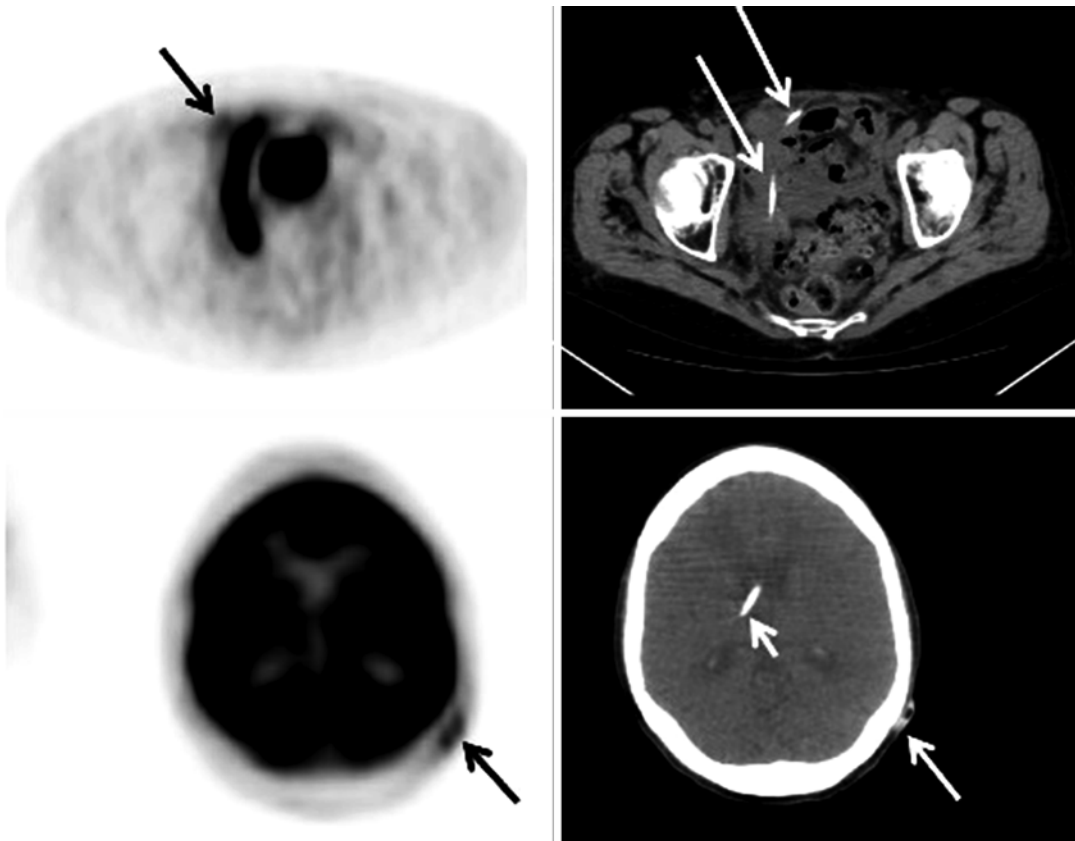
Axial [^{18}F]FDG PET/CT images of the pelvis and head of a 75-year-old woman with lung cancer showing linear [^{18}F]FDG uptake along the pelvic end of the ventriculoperitoneal (VP)-shunt catheter and focal uptake in the VP-shunt reservoir in the scalp. The ventricular end of the VP-shunt catheter was seen in the right ventricle
